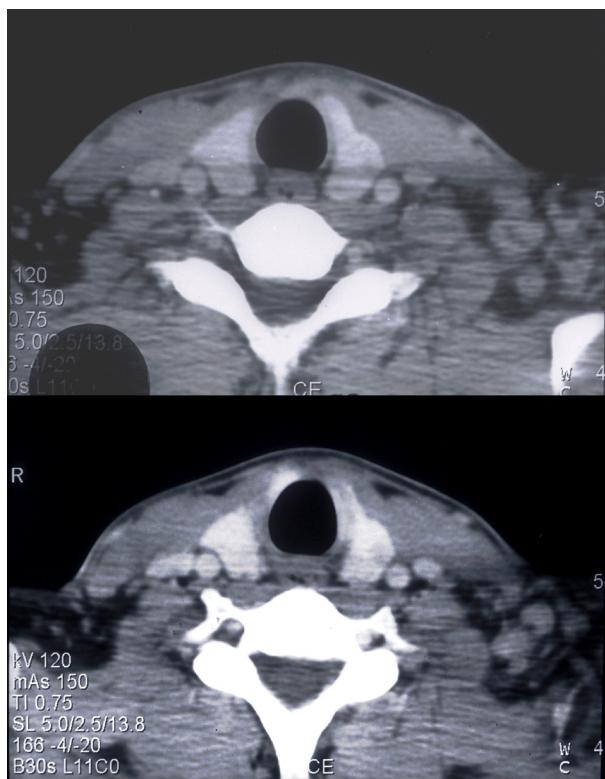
The neck CT scan showed multiple, enlarged lymph nodes with some central necrosis in the left posterior triangle and supraclavicular area.
